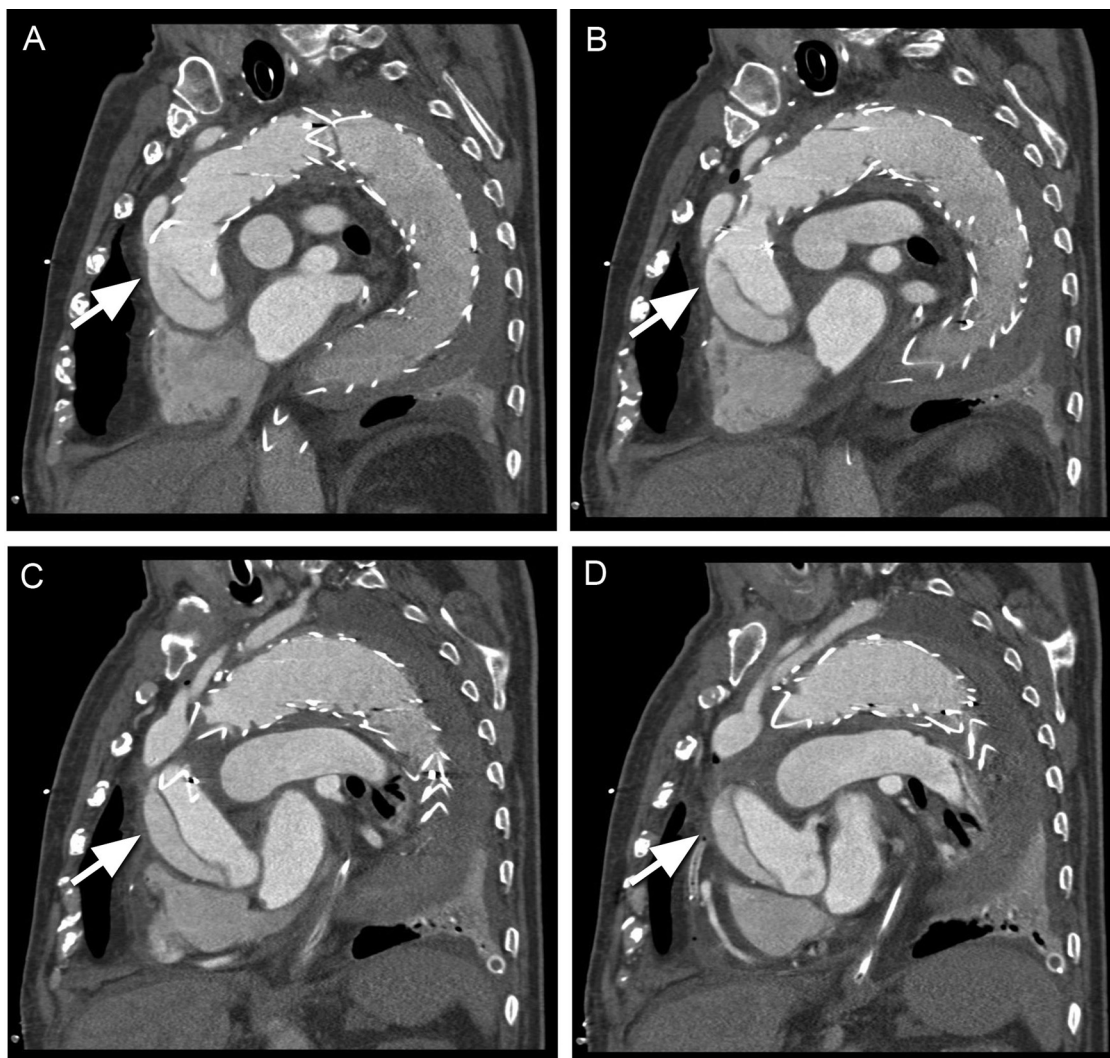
Computed tomography (CT) of the chest shows retrograde type A dissection involving the ascending aorta and the aortic root (panel A-D).
